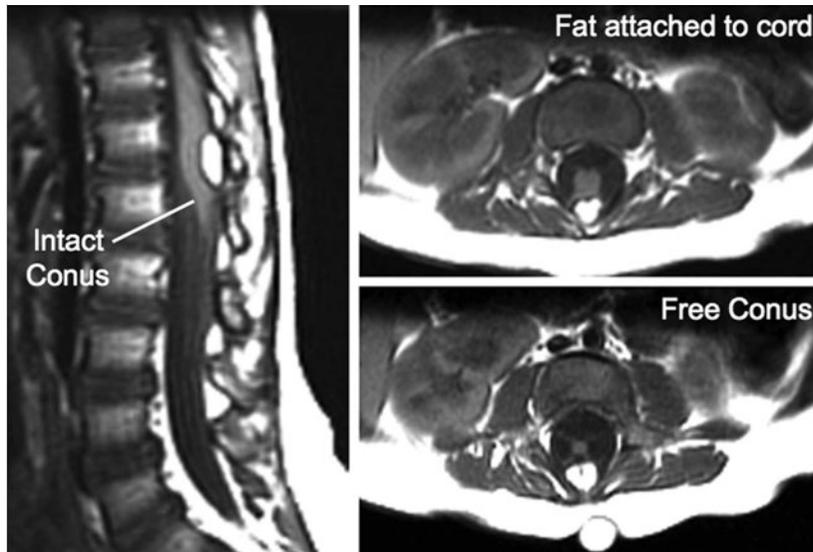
Dorsal lipoma on magnetic resonance images. Sagittal image: Intact conus is caudal to the lipoma stalk. Axial images: Upper image shows site of lipoma attachment to cord; lower image shows free conus just caudal to the level of the lipoma attachment.
